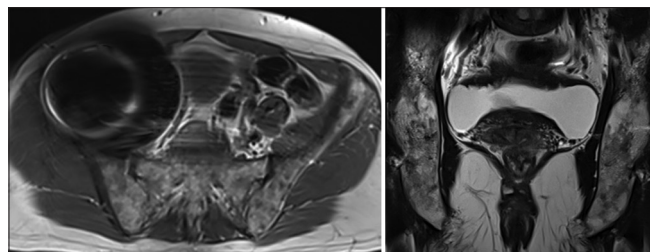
Transaxial T1-weighted and coronal T2-weighted magnetic resonance imaging images show numerous low signal lesions in the pelvic bones consistent with skeletal metastases
